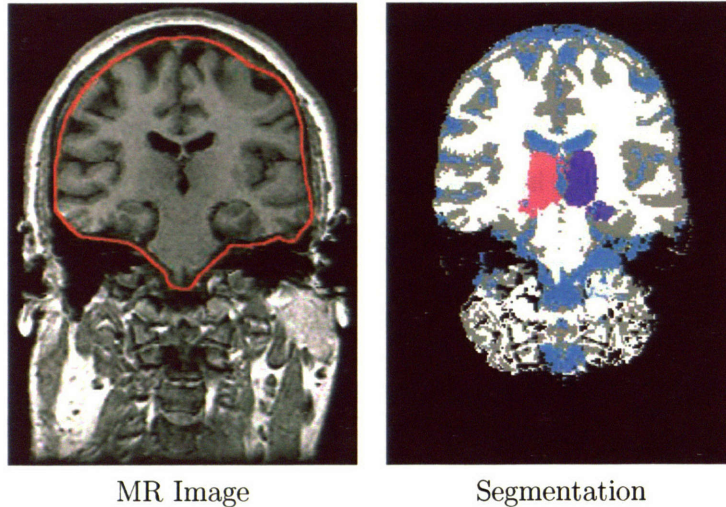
For this MR image our novel approach achieved a suboptimal result as it failed to differentiate the neck from the brain (outlined in red.) See text for detail discussion.
